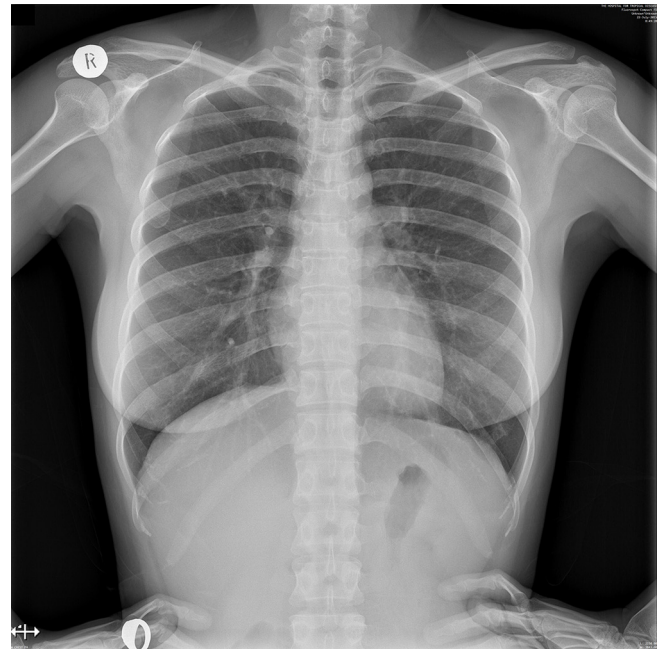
The followed-up chest radiograph showed complete clearing of pulmonary infiltration.
